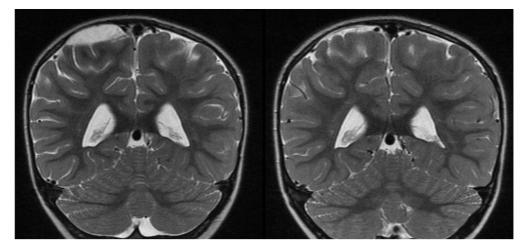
MRI with contrast in coronal section showing comparatively the evolution of complete resorprion of the extra-axial hemorrhagic collection over 45 days.
